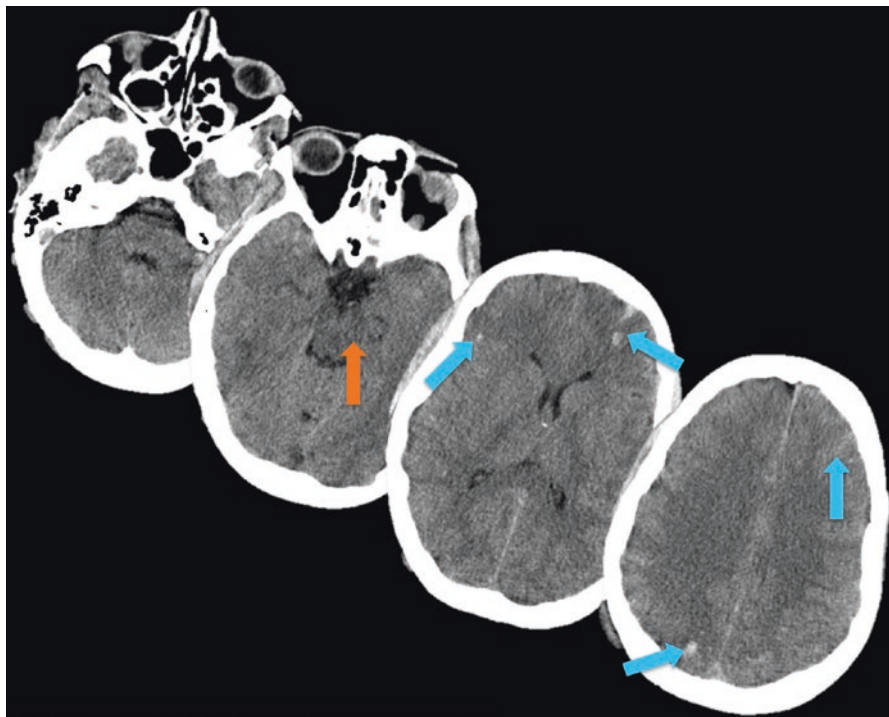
Non contrasted axial CT of the head. Relevant findings are mild compression of the basal cisterns (*orange arrow*) and small areas of hyperdensity in the subarachnoid space and also intra parenchymal area suggestive of contusions
